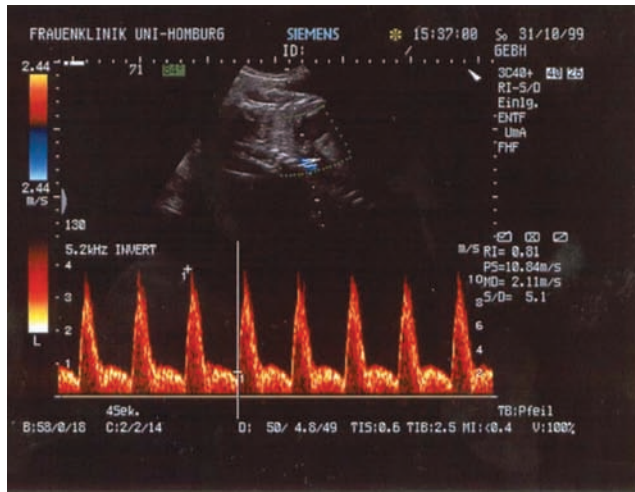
Doppler sonography of fetal aorta with a pulsatile pattern.
